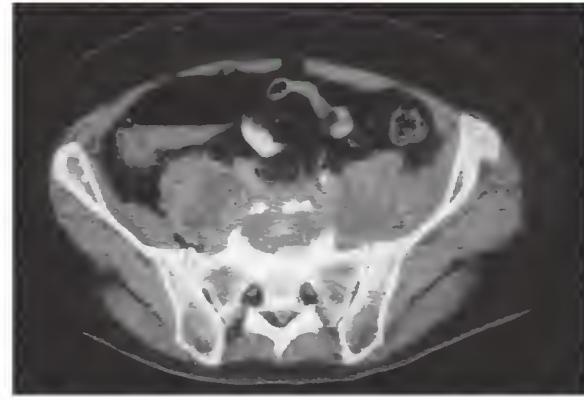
Spinal infection imaged by computed tomography of the lumbar spine. At the L5/S1 level, lucent areas in both psoas muscles and destructive changes in the intervertebral disk space suggest the presence of spinal infection with bilateral abscesses.
